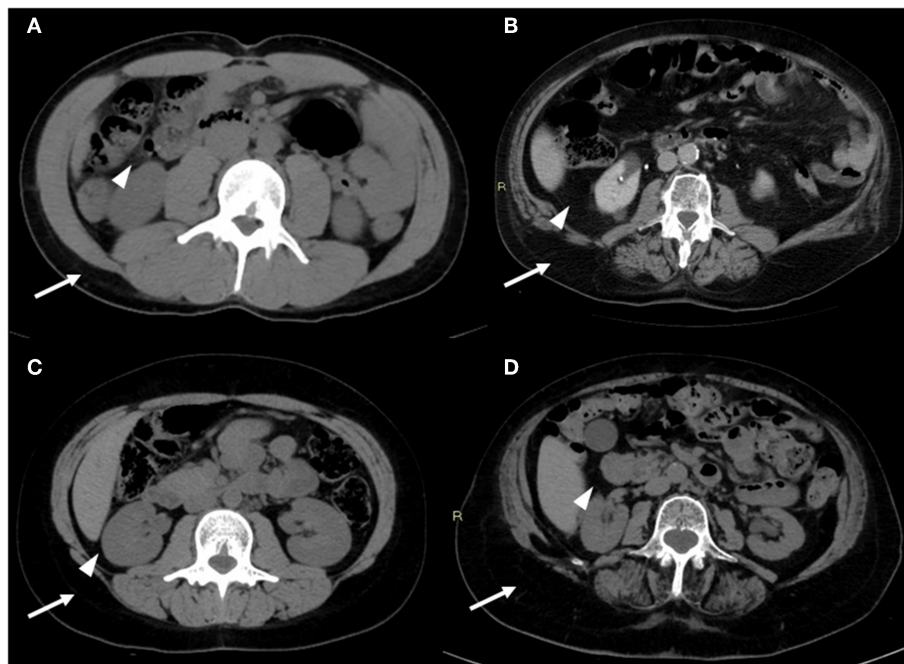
CT images of the android region. CT image slices of the android region showing changes in adiposity distribution (visceral fat—arrowheads; subcutaneous fat—arrows) depending on age and sex: (A) young male, (B) old male, (C) young female, (D) old female. With advancing age, there is a redistribution of fat mass compartment with increase of visceral compartment for both sexes (in particular for males); it is also noteworthy that the subcutaneous compartment is prevalent in females, both in young and old age. Images are kindly provided by IRCCS Rizzoli Orthopedic Institute, Unit of Diagnostic and Interventional Radiology (2019).
